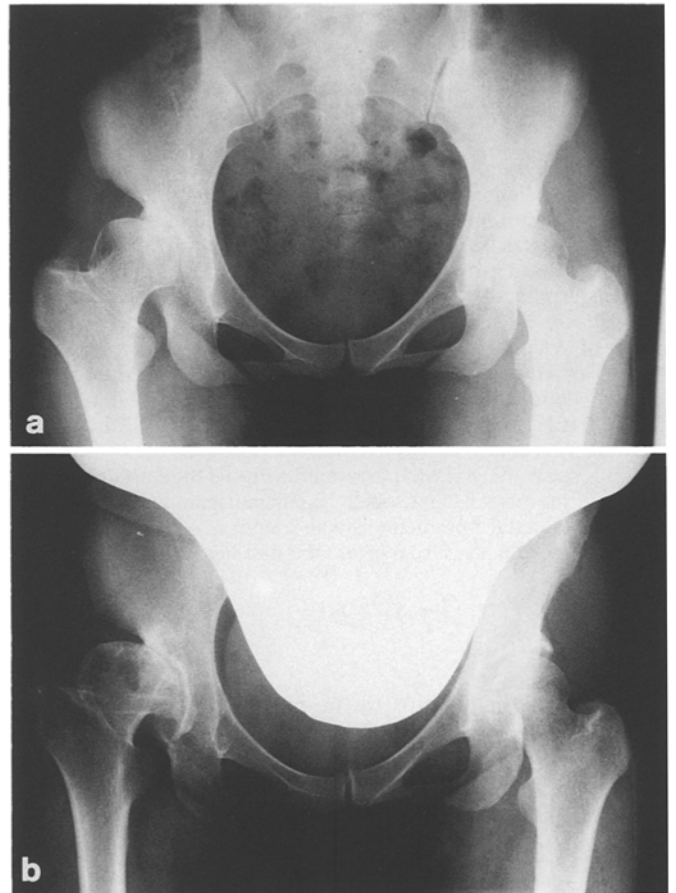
Radiographs of a 23-year-old woman with bilateral osteoarthritis of the hip. She has a past history of treatment for CDH. The right hip showed subluxation and an irregularly shaped femoral head; the CE angle was -20° and AHI was 33. Seventeen years after her first consultation, the right hip, as expected, had developed advanced OA, but the left hip showed natural healing of the acetabulum and the CE angle was restored from 17° to 22°
